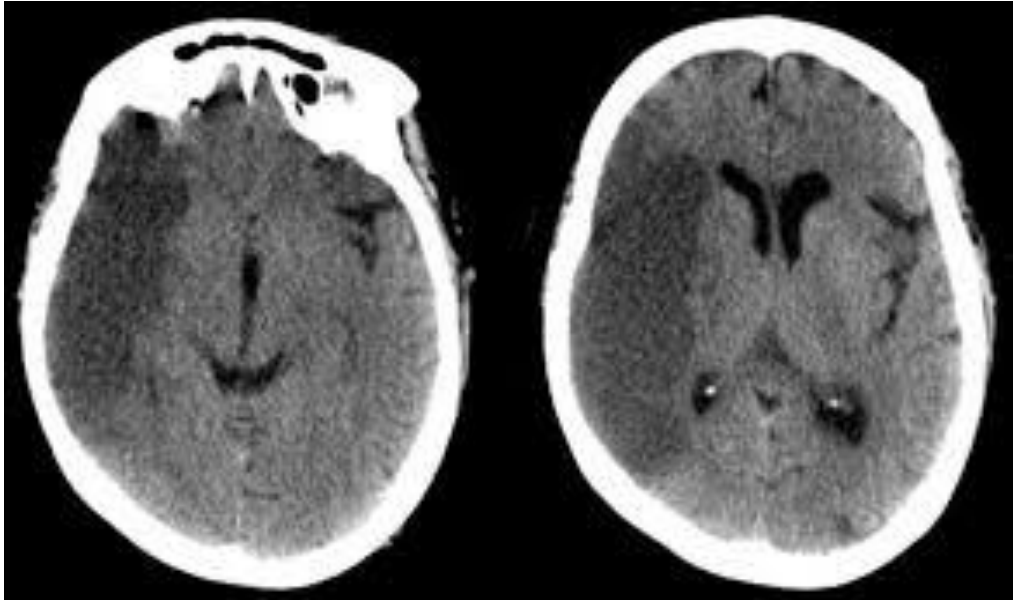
CT with frank ischemic infarction.
